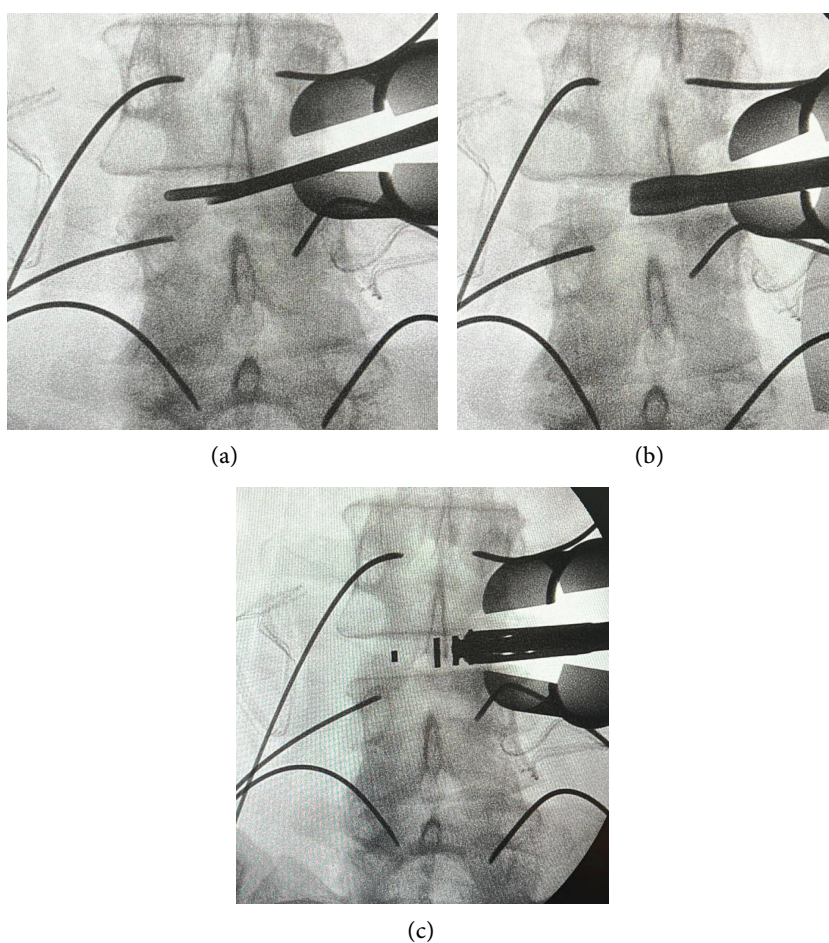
(a) After opening the annulus fibrosus, the resection of the intervertebral disc begins, even managing to remove the disc beyond the midline. (b) In many cases, the narrowness of the space does not allow an adequate discectomy, so the use of small shavers or dilators and increasing them progressively allows the space to be expanded and facilitates disc resection in addition to preparing the platforms of the vertebral bodies. (c) After removing as much disc as possible, the interbody cage is placed under direct vision and supported by X-rays. With the aforementioned exposure, the retraction of neural structures should not be necessary.
